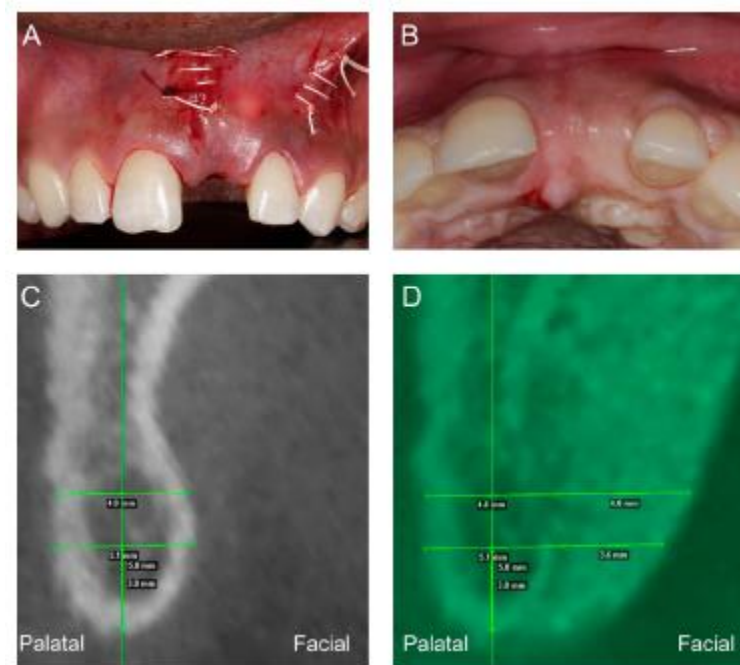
Example CBCT Overlay (anterior site). A) Wound closure for primary intention healing. The #9 site received a dense polytetrafluoroethylene membrane with fixation and a freeze-dried bone allograft. B) Incisal view of the site five months following ridge augmentation. C) Baseline CBCT volume. D) Superimposed baseline and post-augmentation CBCT volumes. In this case, $\Delta V = 0$.
